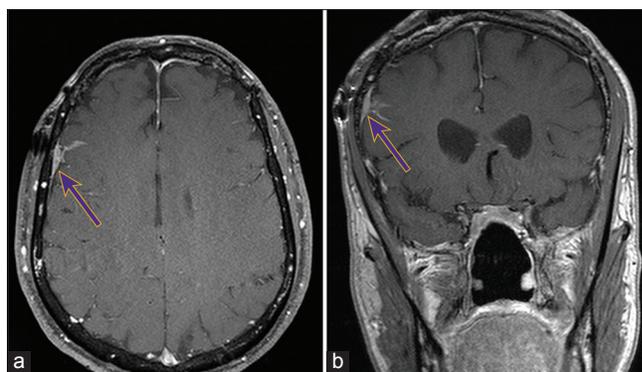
Axial (a) and coronal (b) T1-weighted magnetic resonance imaging showing contrast-enhancing dural-based lesion with parenchymal invasion along the right frontal lobe (arrow)
